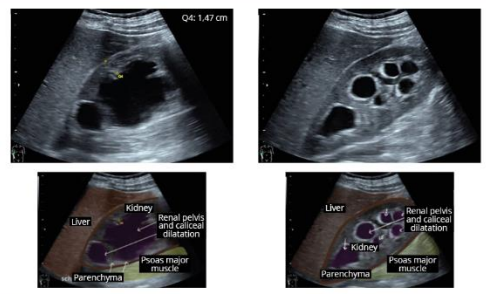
Right kidney, sagittal view: Pay attention to the sonographic findings in the event of increasing urinary retention (caliceal dilatation, thinning of the cortex, reduced sinus reflex, obtuse fornix angle, flattened papillae) → Hydronephrosis Grade 3-4
